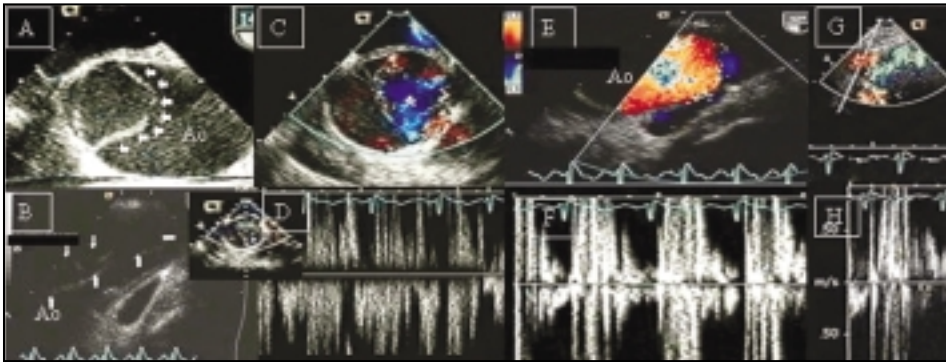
Photographs of transesophageal echocardiogram (A–F) and transcutaneous ultrasound (G, H) of the aortic root, aortic arch, and left innominate artery obtained following the development of a second episode of acute chest pain in patient 1. (A, B) A dissection flap within the aortic root extending into the aortic arch (white arrows). (C, D) Color Doppler and pulsed-wave Doppler images obtained within the true lumen at the aortic root, showing evidence of turbulent systolic blood flow. (E, F) Color and pulsed-wave Doppler images obtained within the true lumen of the distal ascending aorta (Ao), showing evidence of turbulent systolic blood flow. (G, H) Color and pulsed-wave Doppler images obtained within the innominate artery, showing evidence of turbulent systolic flow within the innominate artery.
